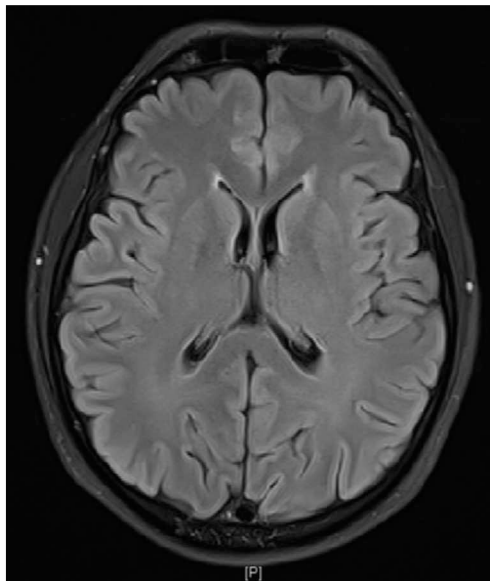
On the second week of therapy DWI (a), ADC (b) and FLAIR (c) sequences showed complete regression of the lesions.
